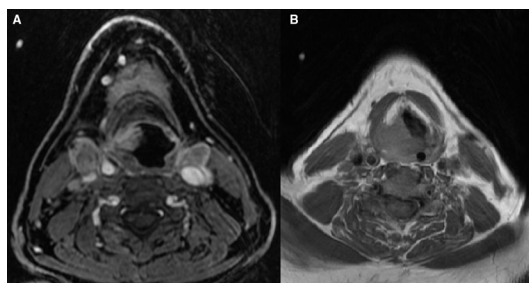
Axial T1-weighted contrast images showing (A) bilateral cervical lymph nodes at level 2 and (B) right supraglottic growth invading thyroid cartilage.
